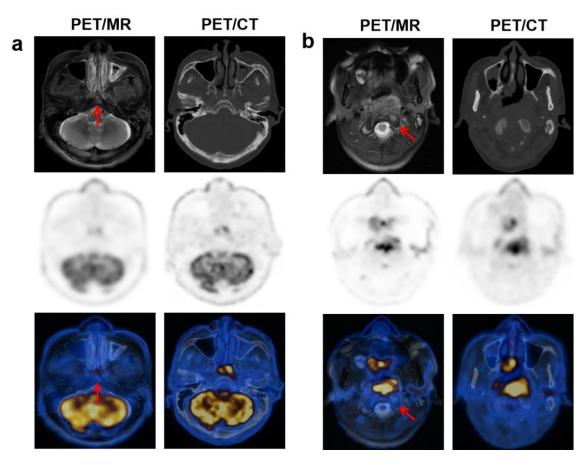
Detection of skull base bone involvement. Each panel: top (MRI or CT), middle (PET), and bottom (fused image). PET/CT was unable to determine the clivus (a, red arrow) and left massa lateralis atlantis (b, red arrow) involvement, while PET/MR revealed their signal abnormality with hyperintense areas on T2-fs.
